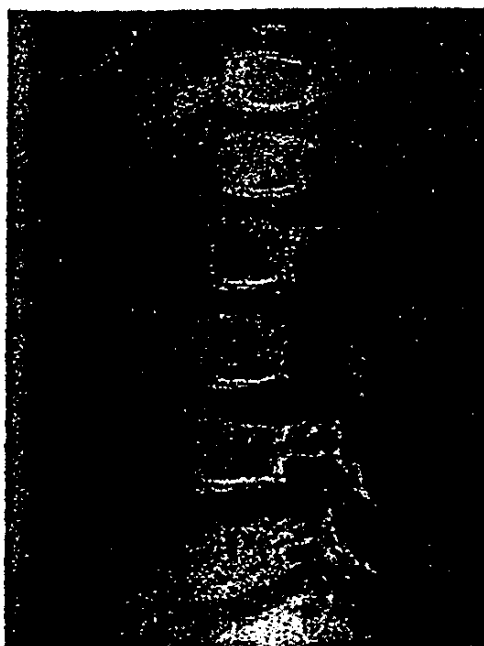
Lead lines are seen in this x-ray of the vertebral bodies. (Courtesy of Dr. Harvey White, Children's Memorial Hospital, Chicago.)
